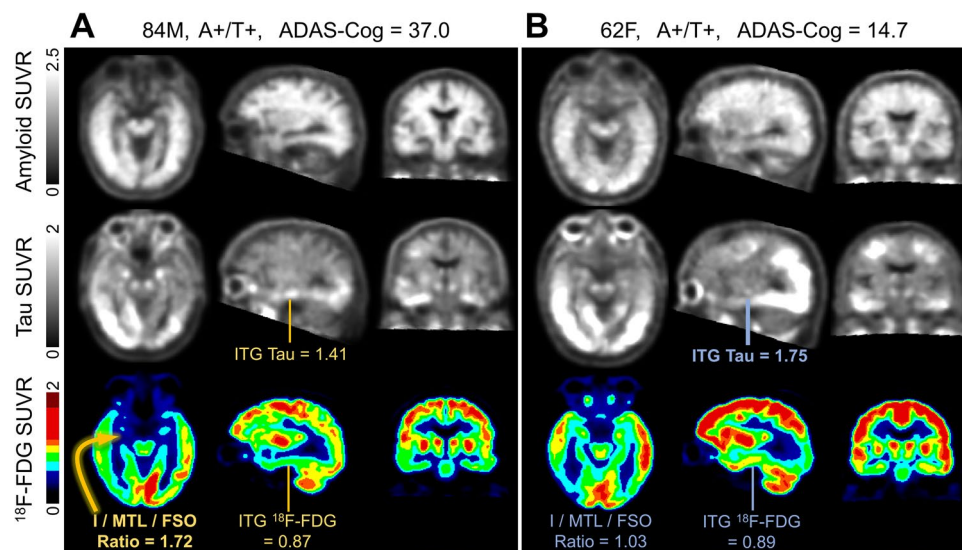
Limbic PET imaging patterns in susceptible and resilient patients with similar ^{18}F -FDG standardized uptake value ratio (SUVR 0.87 to 0.89) but different tau load (SUVR 1.41 to 1.75) in the inferior temporal gyrus (ITG). ^{18}F -Florbetaben (amyloid), ^{18}F -Flortaucipir (tau), and ^{18}F -FDG PET scans are shown for a A cognitively impaired 84-year-old male with amyloid+/ τ + status and AD Assessment Scale-Cognitive (ADAS-Cog) score of 37.0 (higher is worse) and a B cognitively impaired 62-year-old female
